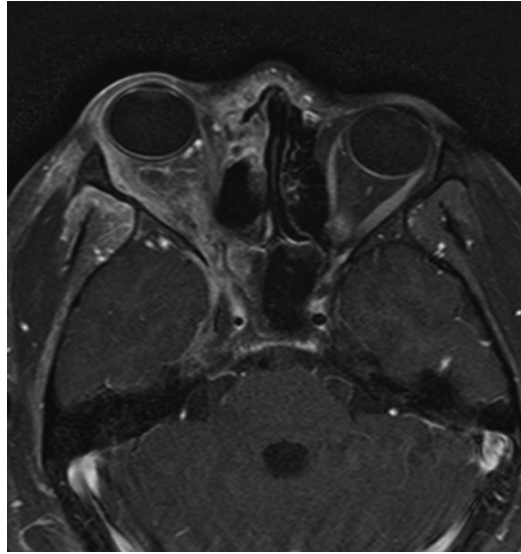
Invasive fungal sinusitis with extension into the right orbit and intracranially. Invasive fungal sinusitis in an adolescent with poorly controlled type 2 diabetes. T1-weighted MRI. Right maxillary sinus with extensive disease with extension into the right orbit. This patient presented with severe headaches and facial pain. He underwent debridement and was initiated promptly on voriconazole and amphotericin. Cultures grew *Rhizopus*. The child and his family denied radical surgical debridement. Despite maximal medical management the child's disease progressed and he subsequently expired
